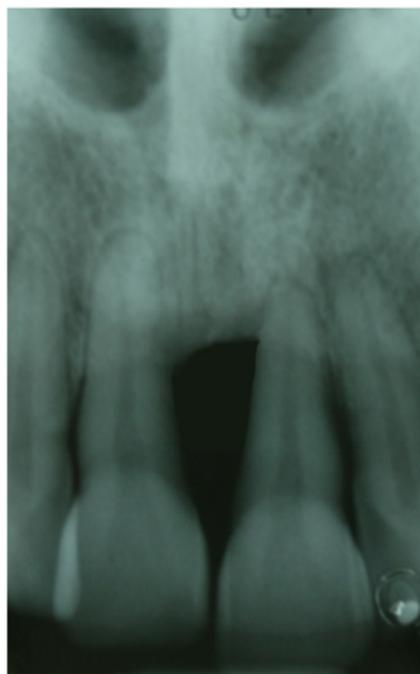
Figure N 12a: Case Report n. 2 Periapical Rx preoperatory.
